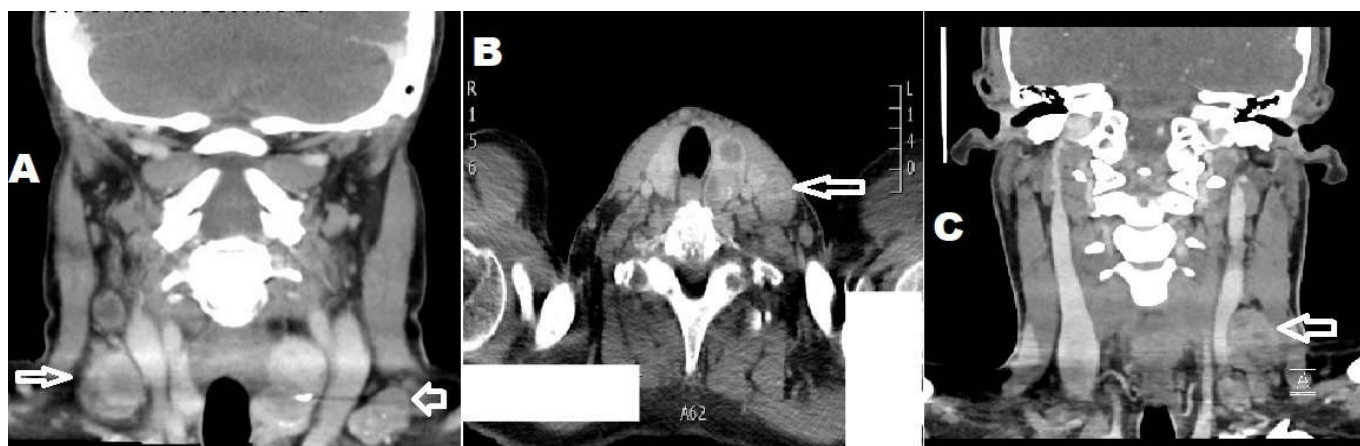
Pre-operative Neck CT showing (A) bilaterally enlarged cervical lymph nodes at levels I, II and III, (B) multiple thyroid nodules with enlarged left cervical lymph node level III, (C) multiple pathological enlarged lymph nodes in the left cervical level III/IV; the largest one with central necrotic foci compressing the adjacent left jugular vein.
